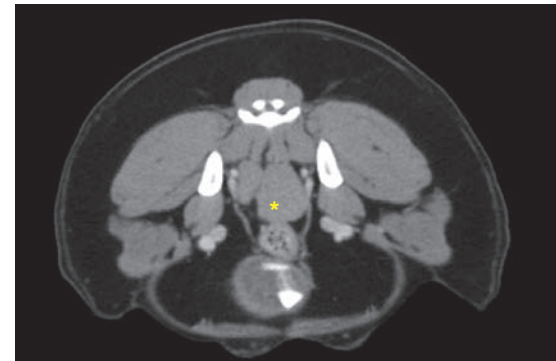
CT image showing lymph node metastasis of anal sac adenocarcinoma marked with yellow asterisk.*
